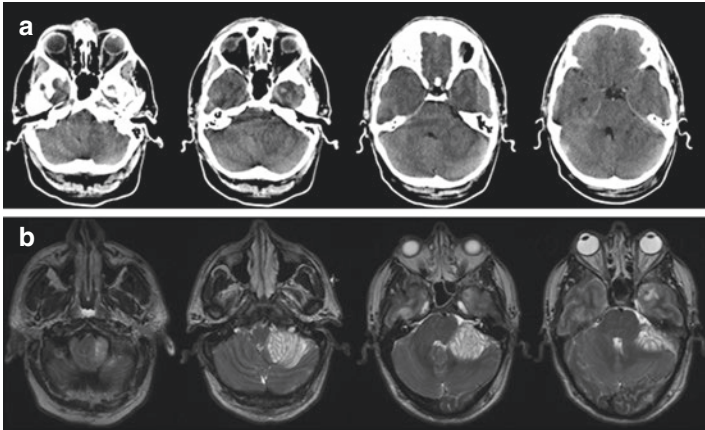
A 39-year-old male with no previous illness fell off a roof while working on cables. He took to bed to get better but had persistent headaches and vomiting so he reported to the Emergency room of his local hospital. The non-contrast CT scan (a) was obtained. In the setting of trauma, the left cerebellopontine angle mass could easily have been overlooked by a beginner, but it is obvious on the MRI scan. It is important to pay attention to the posterior fossa in all scans because of the ease with a lesion can be missed. The tumor (Lhermitte-Duclos disease—dysplastic gangliocytoma) is obvious on the subsequent MRI
